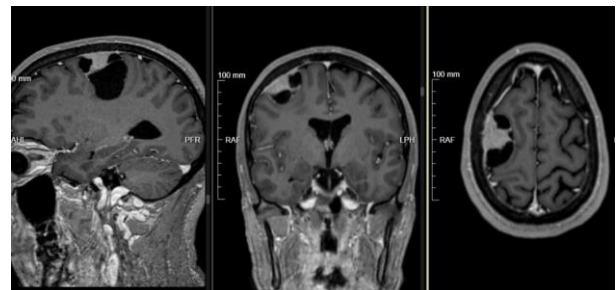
Pre-operative MRI showing cystic meningioma classified by Nauta as type 4.
